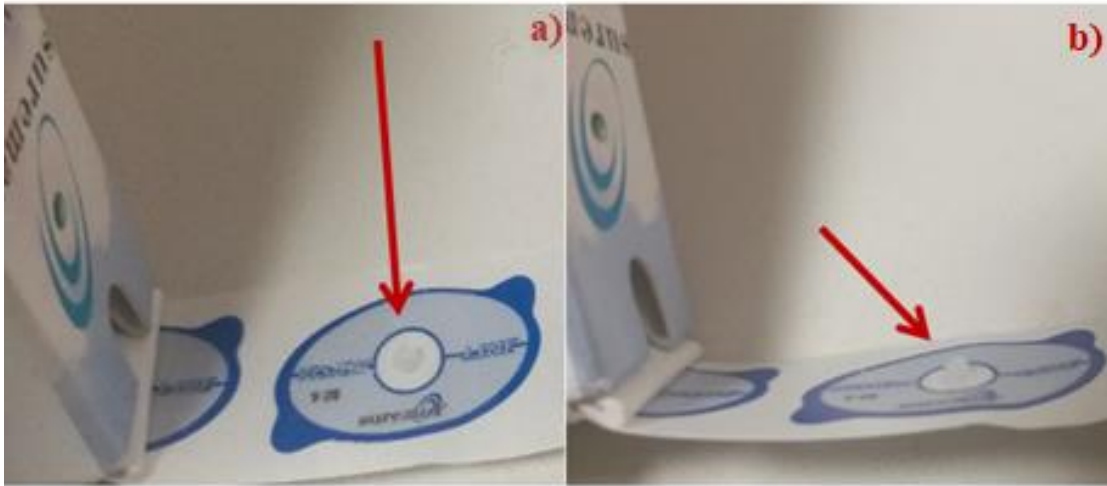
Different Views of a Representative CT Marker a) Top View, b) Side View, Ankara University Faculty of Medicine Department of Radiation Oncology
